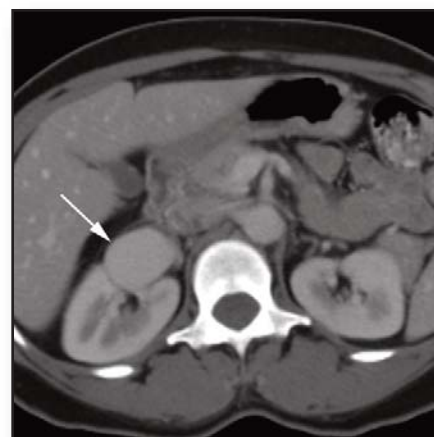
CT demonstrating renal aneurysm
